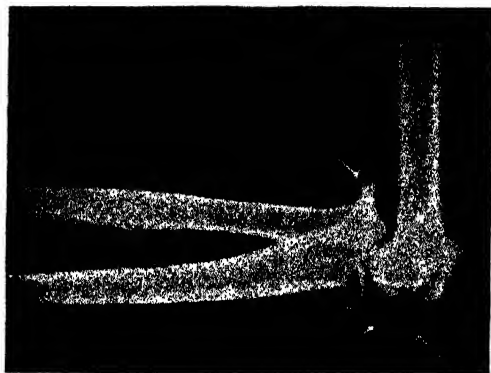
FRACTURE OF THE ELBOW JOINT. This x-ray shows that dislocation is also present.
